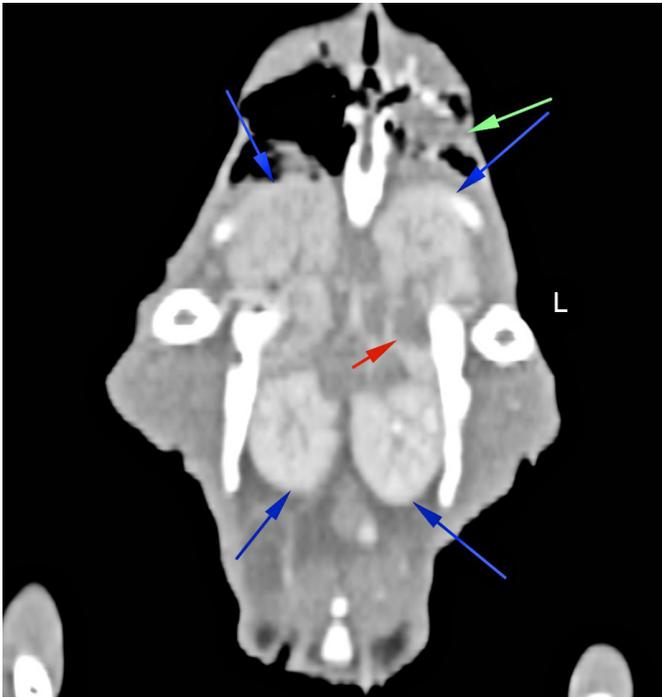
CT Coronal Plane Case 2. Blue arrows - left and right kidneys. Red arrow - tumour infiltration of the left kidney (adjacent to the ureter filled with contrast). Green arrow - metastasis/tumour infiltration in the left lung. Compare to Figure 1.
